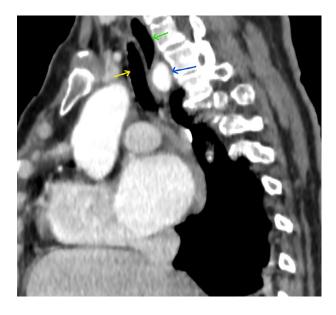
Postcontrast computed tomography—angiography sagittal image shows an arteria lusoria (aberrant right subclavian artery) (blue arrow) / esophagus (green arrow)/ trachea (yellow arrow).
